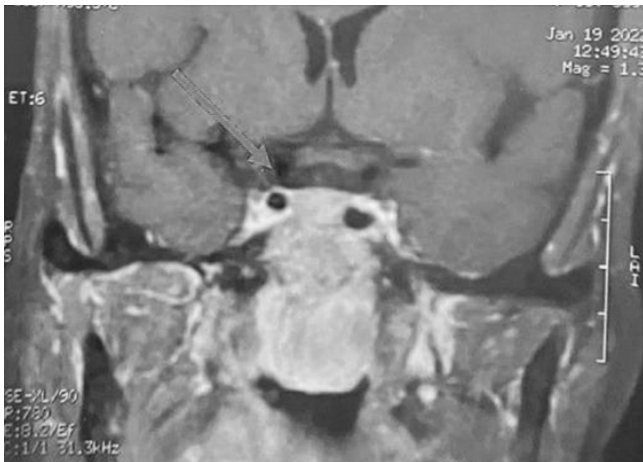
Nasopharyngeal MRI in coronal section, T1-weighted image: showing the enhanced nasal tumor near the sella turcica (arrow)
